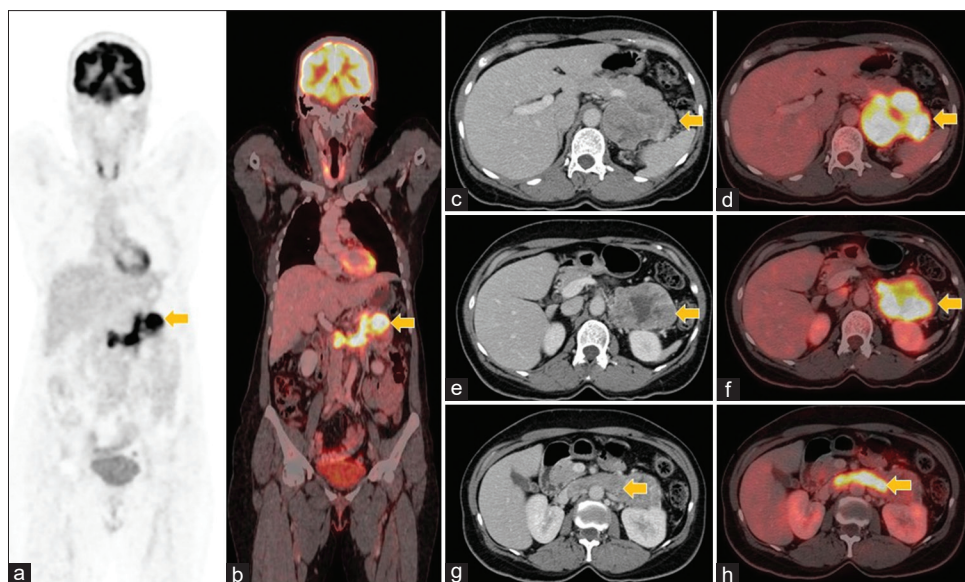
Staging ^{18}F -fluorodeoxyglucose positron emission tomography-computed tomography scan coronal positron emission tomography (a), fused coronal positron emission tomography-computed tomography (b), and corresponding transaxial images (c-h) showing fluorodeoxyglucose-avid large heterogeneously enhancing left adrenal lesion with tumor thrombus infiltrating the left renal vein and adjacent inferior vena cava
